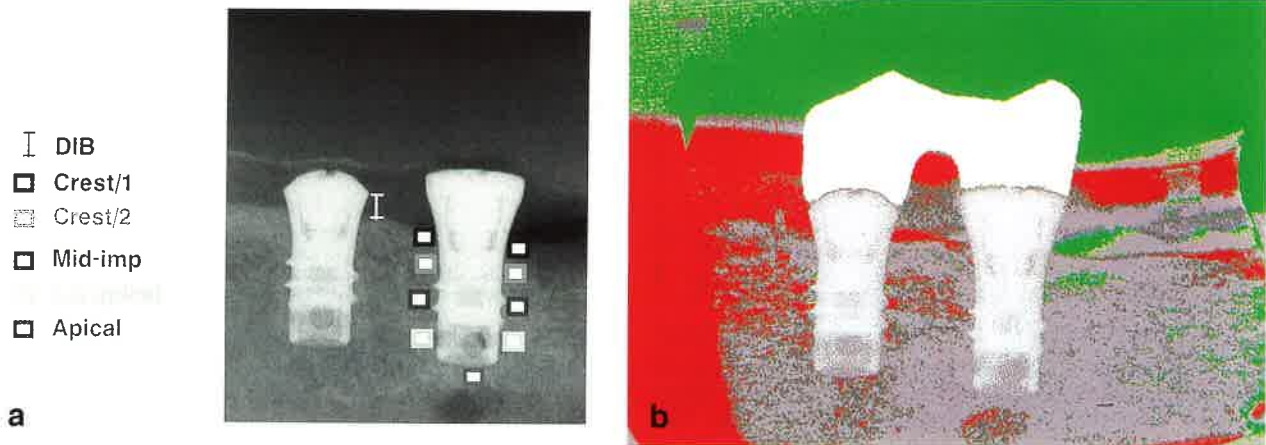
(a) Baseline X-ray - left implant: vertical line indicates linear measurements for the evaluation of the distance between the implant shoulder and the most coronal bone-to-implant contact (DIB) - right implant: boxes defining areas-of-interest (AOI) at different levels for computer-assisted densitometric image analysis (CADIA). (b) Colour converted subtraction image, comparing 12 months of loading versus baseline. Typical remodeling changes are displayed. Red areas indicate regions of bone gain, green areas regions of bone loss. Note bone gain in the most coronal area of the bone crest. No changes were detected in more apical regions.
